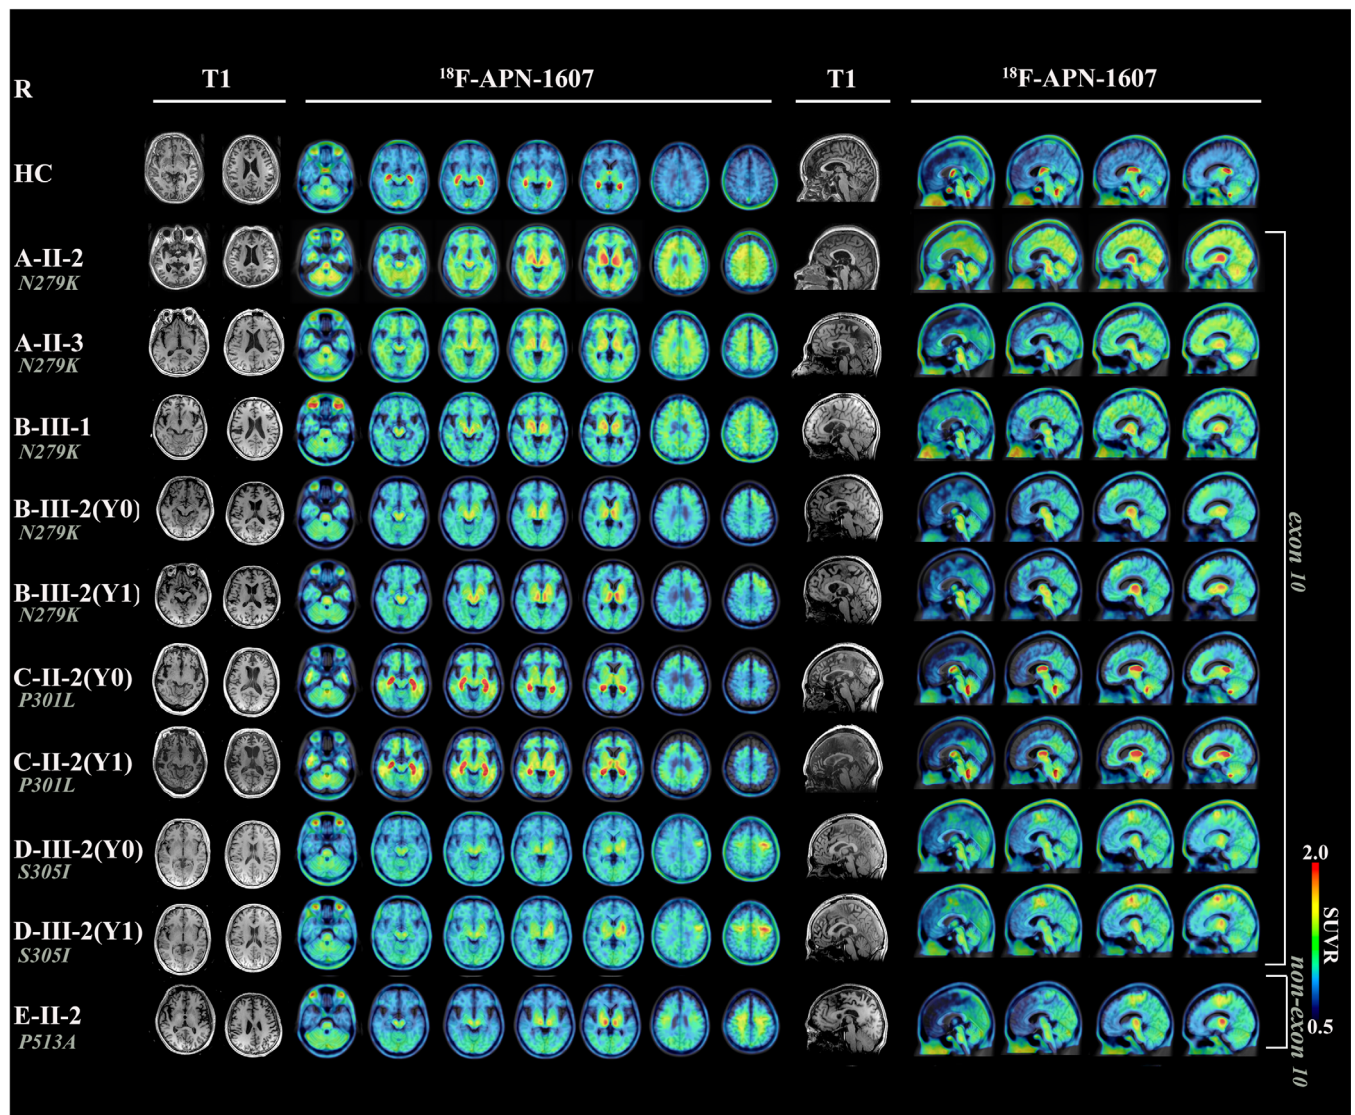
¹⁸F-APN-1607 binding patterns observed in MAPT mutation carriers and healthy control subjects: baseline and follow-up data. Each patient is presented separately; the MAPT mutation identified for each case is marked in italics. Y0 denotes baseline findings, whereas Y1 refers to follow-up findings. The patterns of tau depositions were heterogeneous across different MAPT mutations. Compared with baseline values, the three patients who were longitudinally followed up (B-III-2, C-II-1, and D-III-2) showed an increased tau burden over time. HC, healthy control subject; R, right; SUVR, standardized uptake value ratio. [Color figure can be viewed at wileyonlinelibrary.com]
